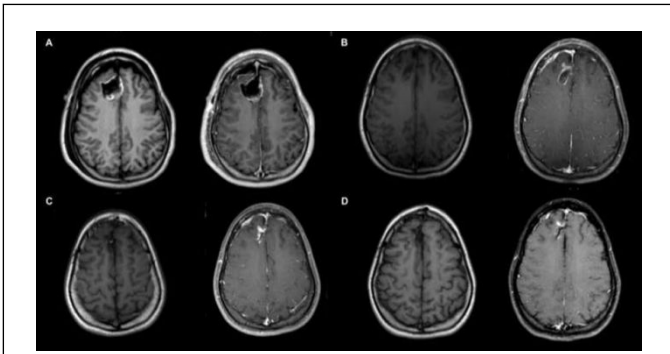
(A) Immediate post-operative T1 noncontrast MRI (left) and contrasted study (right) with no residual enhancement noted. (B) 3-month post-op with some enhancement around the lateral anterior border of resection cavity, possible radiation vs. post-treatment reaction. (C) 6 months post-op with stable enhancement along the lateral anterior resection cavity (D) 12 months post-op with decreased enhancement at resection cavity
